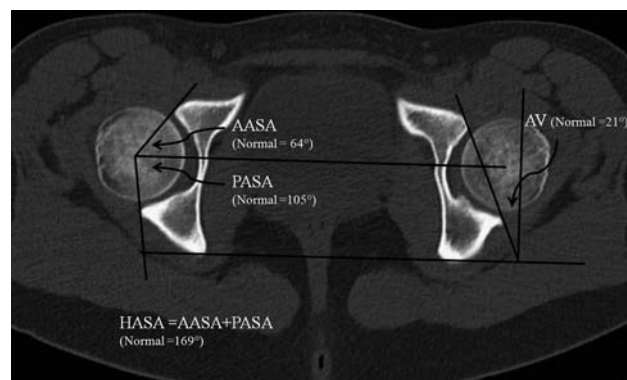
Two dimensional transaxial computed tomographic scan shows measurements: anterior acetabular sector angle (AASA), posterior acetabular sector angle (PASA), horizontal acetabular sector angle (HASA), and acetabular version (AV).
